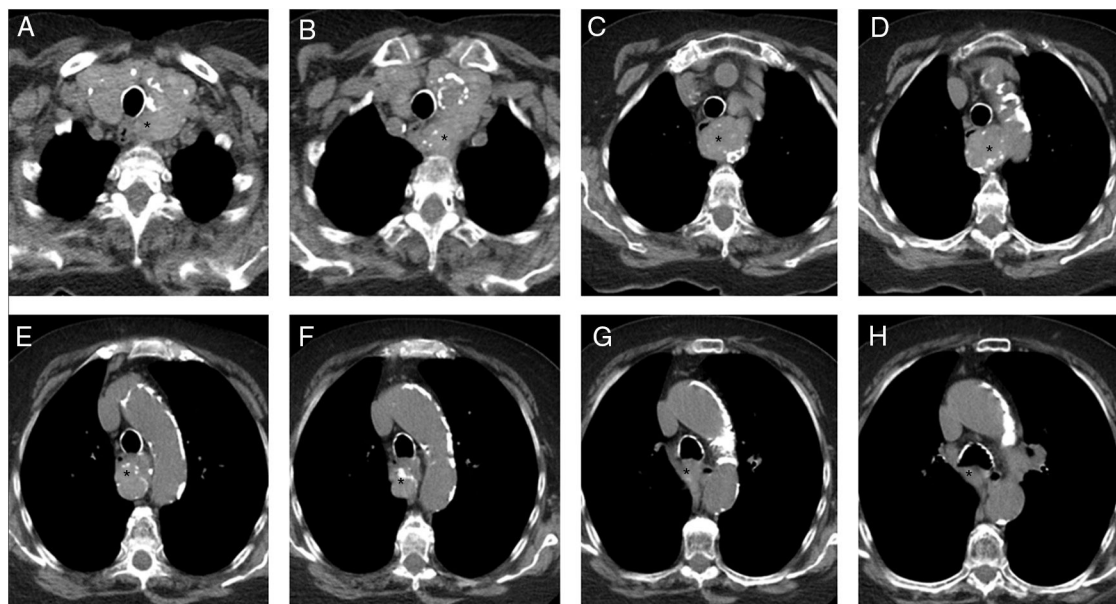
Non-contrast consecutive CT scans of the chest demonstrated a large calcified mass (asterisk). The mass extends to carina level.
